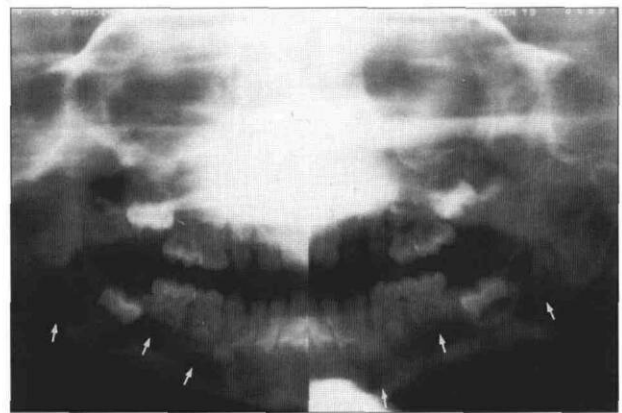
Panoramic radiograph of the patient at 3.6 years of age depicts mandibular involvement often associated with LCH. The numerous lytic lesions are apparent.
